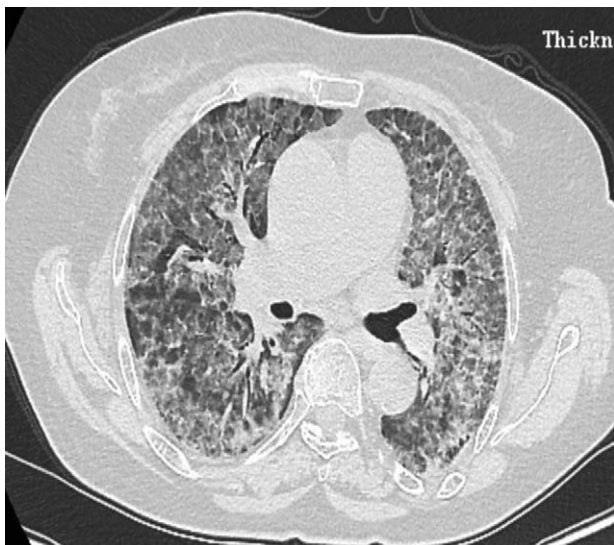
The high-resolution computed tomography of the chest showing bilateral interlobular septal thickening on a background of GGOs.
